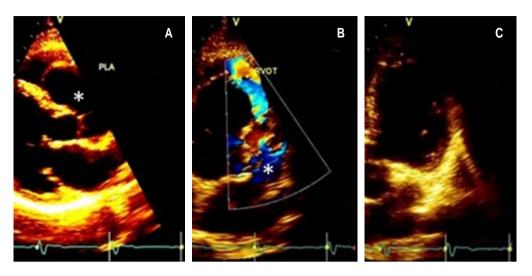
Doppler-echo pre-treatment; the asterisk shows the aneurysm in long (A) and short (B) parasternal and apical (C) view.
